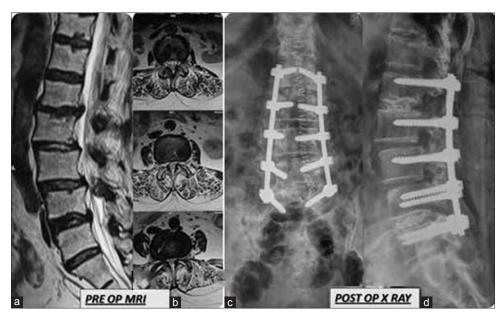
Preoperative MRI T2W, midsagittal (a) and axial (b) images showing multilevel listhesis and canal stenosis. Postoperative x-ray lumbosacral spine anteroposterior (c) and lateral (d) views showing implant (pedicle screws) *in situ* following instrumented fusion
